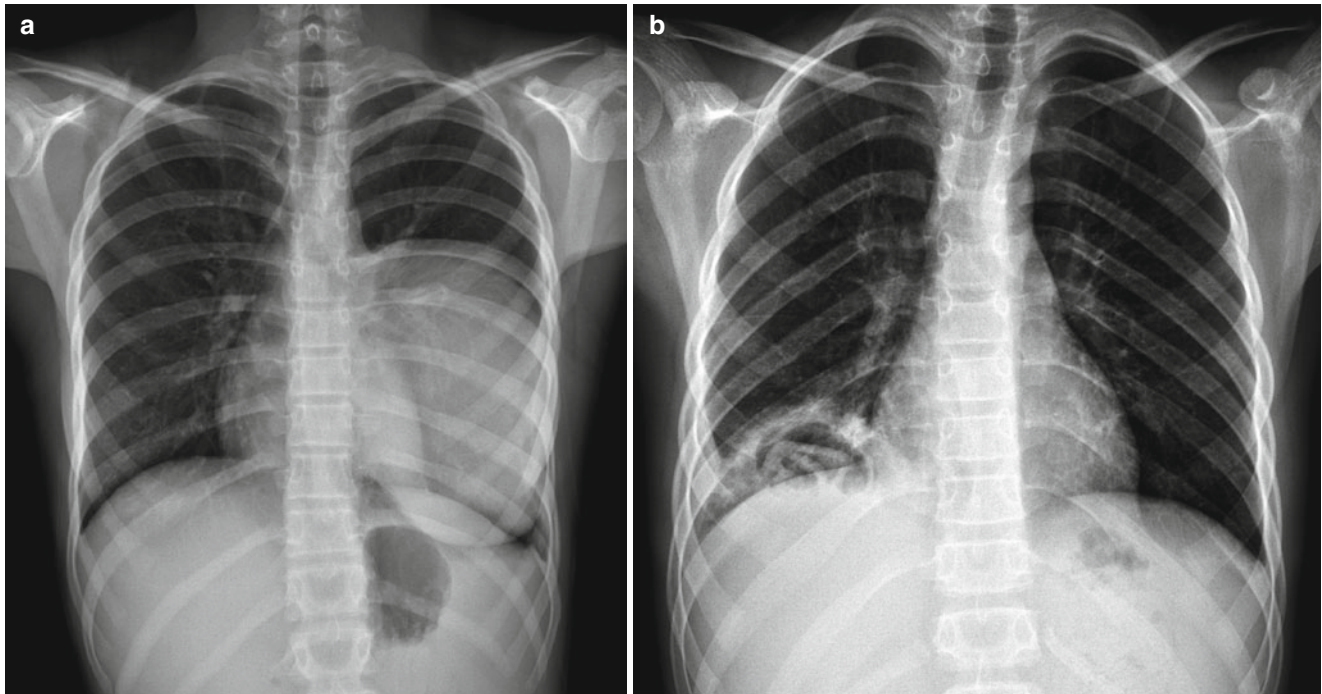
Hydatid disease. (a) Radiograph of a 13-year-old girl who presented with cough and chest pain shows a mass-like opacity in the left lower lobe, later confirmed to be *Echinococcus* infection. (b) A 12-year-old boy with abdominal pain had a chest x-ray showing
